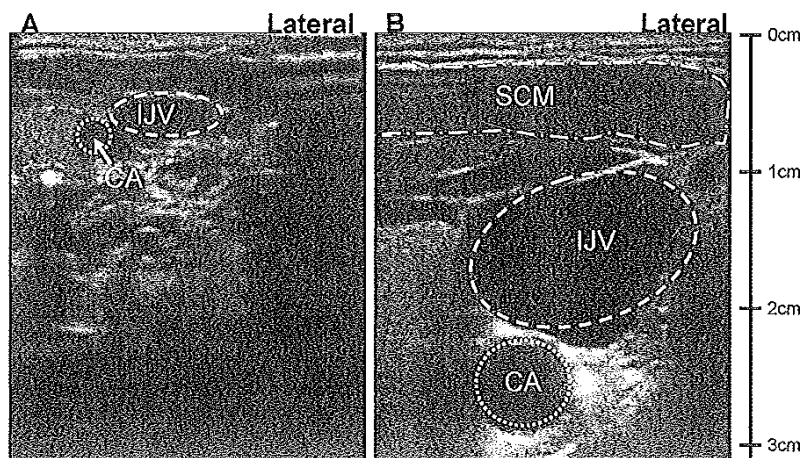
Ultrasound images of the RIJV taken in a 2-month-old infant (A) and adult (B) in the same scale (maximum depth of 3.2 cm). In absolute size, the adult vessels are much larger and deeper than in the infant. In practice, when cannulating an infant's vessel, the image would be magnified to place the vein at half to two-thirds of the depth of the screen (or the maximum resolution of the machine/probe), thus allowing greater resolution of the superficial structures. The anatomy is variable in both adults and children. In this adult, the CA is completely overlapped by the vein and lies deeper than is common. Mean diameter of the vein has been reported as 0.47 cm in infants and 1.94 cm in adults (without associated manoeuvres).
